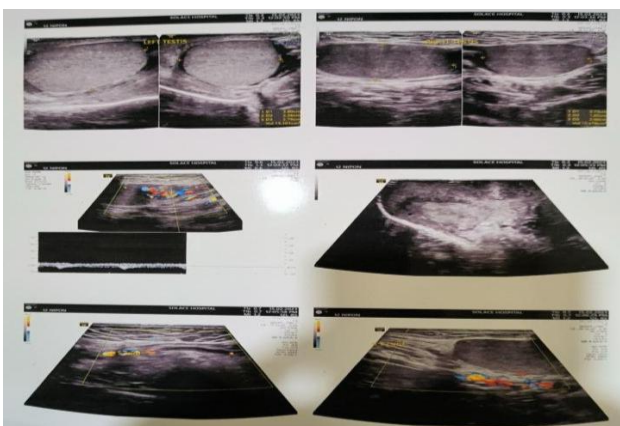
High resolution USG with Doppler of bilateral scrotum, showing hypovascularity in right testis.
